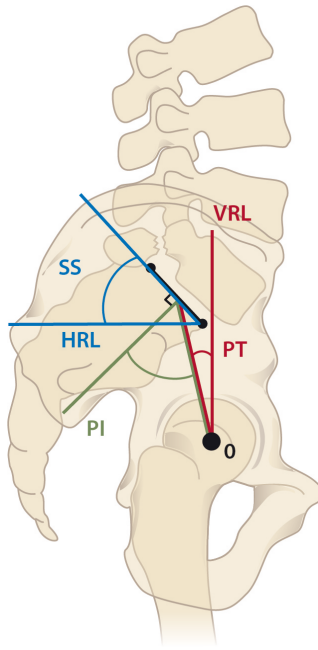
Pelvic measurements (Based on O'Brien et al. Radiographic measurement manual. Memphis, TN. Medtronic Sofamor Danek, 2004.).
